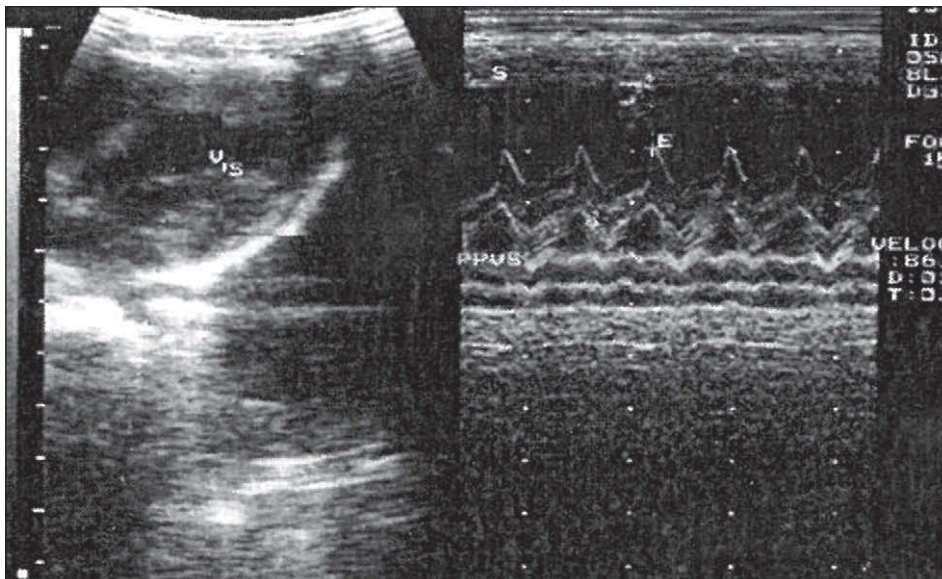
Echocardiography: aorta: 0.9 cm, Left atrium: 1.2 cm, Left ventricle: 2.3/3.1 cm, FE 0.64, FS 32%, mitral E-septum distance: 1.5 cm, synchronous septal-to-posterior wall motion, no liquid in the pericardium. Diagnostic: dilated cardiomyopathy
